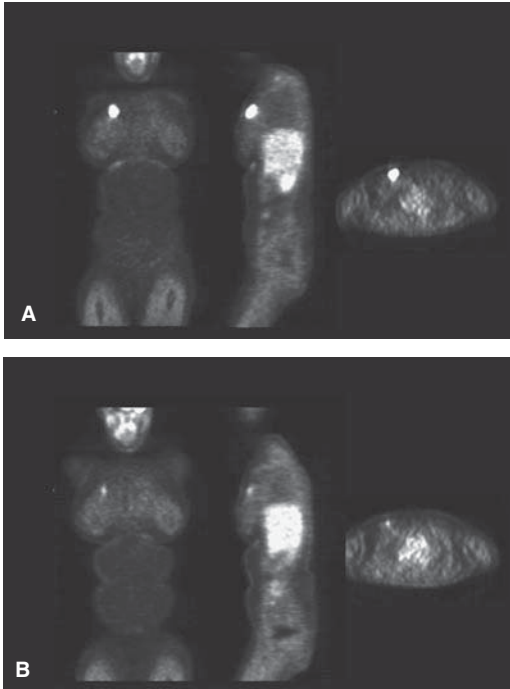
A 52-year-old woman with locally advanced, invasive intraductal breast carcinoma. (A) Prior to chemotherapy, FDG-PET (left) coronal, (middle) sagittal, and (right) transaxial images demonstrate intense uptake in the primary tumor. (B) After chemotherapy, FDG-PET (left) coronal, (middle) sagittal, and (right) transaxial images demonstrate marked reduction in tumor uptake compatible with tumor response to therapy.
